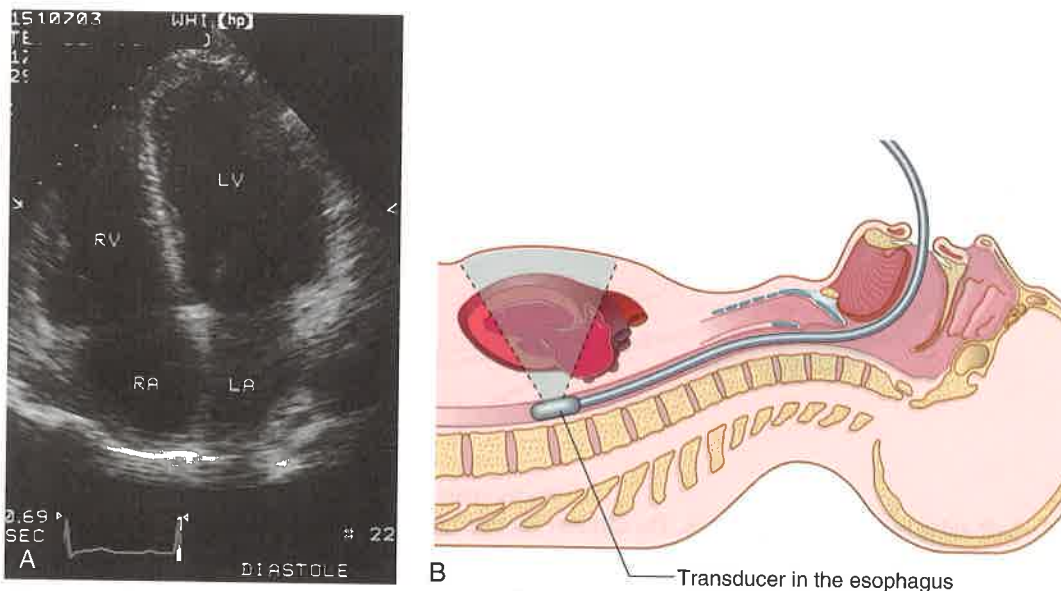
(A) Echocardiogram. Notice that in this view, the ventricles are above the atria. (B) Transesophageal echocardiography. (A, From Goldman L et al: Cecil Textbook of Medicine, 23rd ed., Philadelphia, Saunders, 2008.)
